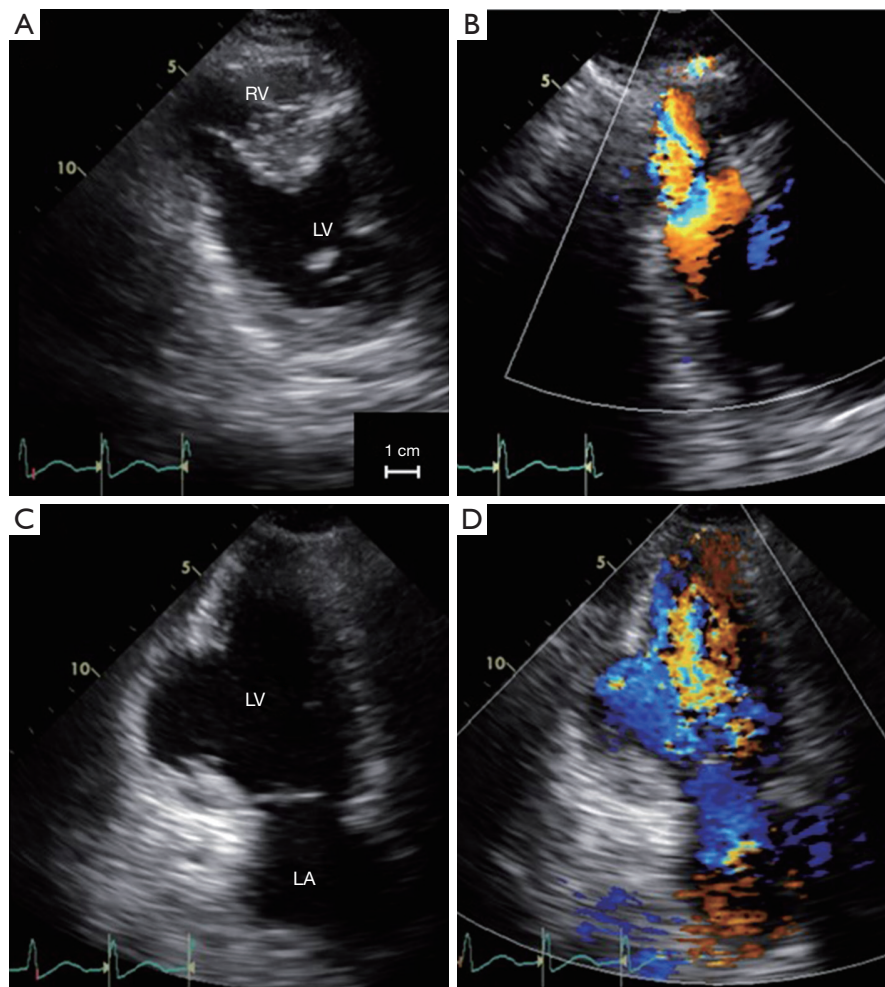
Echocardiography after primary angioplasty. (A) Transthoracic echocardiography in the parasternal short axis view, after transferred to our hospital, showed progressive ventricular septal perforation measuring 18 mm of the diameter; (B) color flow imaging also showed massive shunt flow in comparison with previous examination; (C) echocardiography in the apical two-chamber view showed clear separation of the basal interventricular septum; (D) color flow imaging demonstrated further increases in shunt flow. LV, left ventricle; RV, right ventricle; LA, left atrium.
